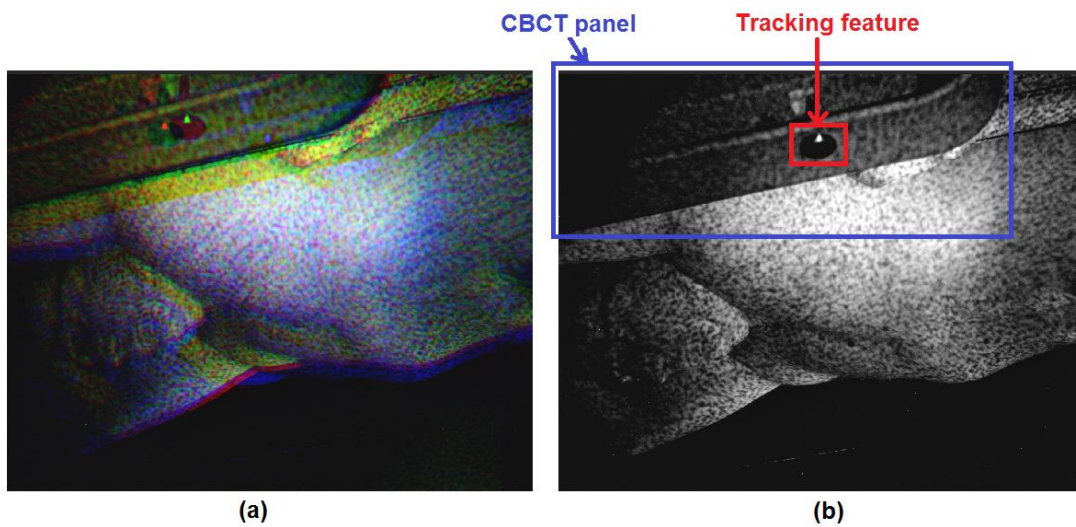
Photos captured by the three cameras of the optical surface imaging system superimposed in a single RGB image (Panel a). The blue image component, including the larger portion of the CBCT panel detector, is extracted from the captured photos (Panel b). The elliptic feature used for the tracking of the CBCT panel motion is shown in the figures.
